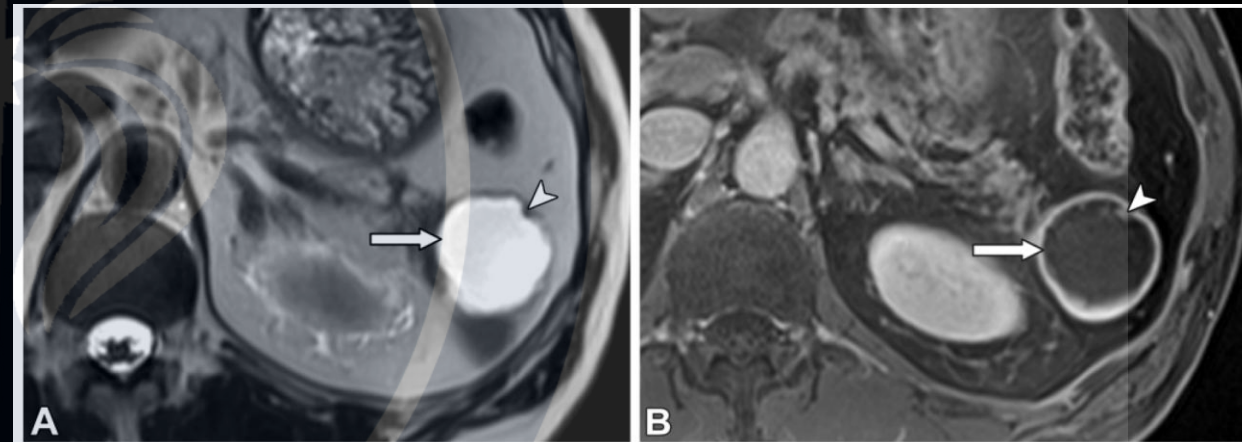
Cystic PNET in a 66-year-old man with a history of prostate cancer, and a pancreatic cyst seen at CT. (A) Axial T2-weighted MR image shows a 4.2-cm cystic lesion (arrow) in the pancreatic tail, with subtle nodularity (arrowhead) along the cyst wall. (B) Axial contrast-enhanced T1-weighted MR image shows a thick enhancing wall and nodularity (arrowhead) of the cystic lesion (arrow). Biopsy yielded World Health Organization grade 1 (carcinoid) neuroendocrine tumor.
